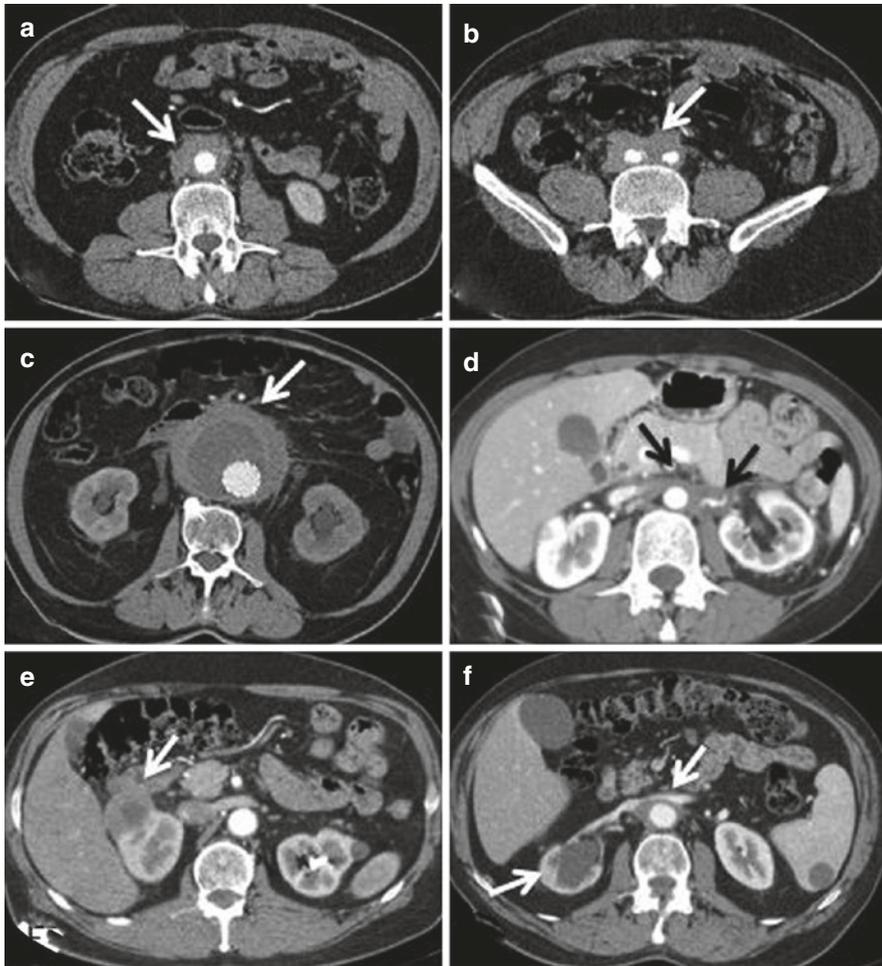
Computed tomography findings in chronic periaortitis. (a, b) Typical aspects of periaortic (a, *arrow*) and peri-iliac (b, *arrow*) idiopathic retroperitoneal fibrosis (RPF). The retroperitoneal tissue develops around the anterior and lateral sides of the abdominal aorta and the common iliac arteries. (c) Typical case of perianeurysmal RPF, with the periaortic tissue surrounding an aneurysmal aorta (*arrow*). Endovascular aortic prosthesis can be seen. (d) Idiopathic RPF surrounds the abdominal aorta (*left arrow*) and encases the origin and the left renal artery (*right arrow*). (e) Renal inflammatory pseudotumor in a patient with chronic periaortitis (*arrow*). (f) In a patient with idiopathic periaortic (*right arrow*) and peri-iliac retroperitoneal fibrosis (not shown), chronic hydronephrosis determined right kidney atrophy (*left arrow*)
